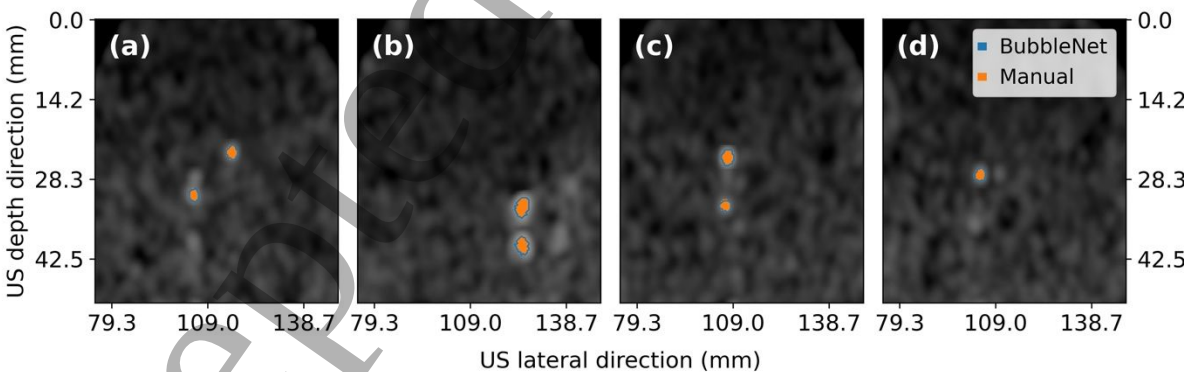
A comparison in segmentation performance on four (a-d) randomly picked differential Ultrasound frames between BubbleNet (blue solid line) and a manual annotator (orange segmentation map) for an unseen dataset with different acoustic imaging settings.
